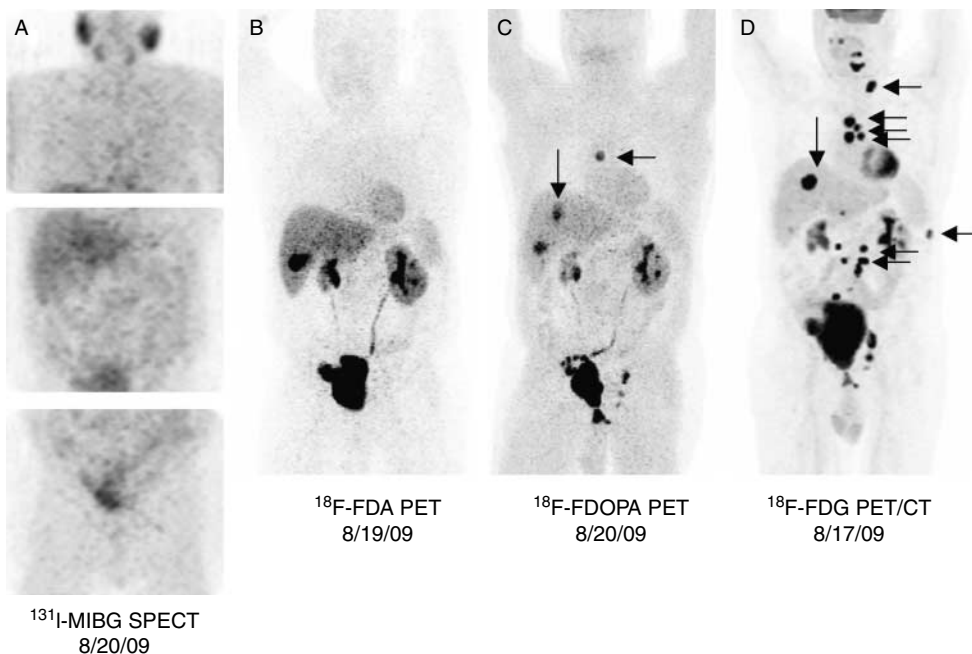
Nuclear imaging studies of a 55-year old male with metastatic pheochromocytoma who tested negative for succinate dehydrogenase B, C, and D mutations. The primary tumor was found in the urinary bladder and was removed with en bloc cystectomy, prostatectomy, with lymphatic node dissection and creation of ileal neobladder in 2005. In 2009, he was diagnosed with metastatic disease with false-negative ^{123}I -MIBG SPECT/CT. At NIH, (A) ^{123}I -MIBG SPECT/CT was also negative, but other nuclear imaging such as (B) ^{18}F -FDA, (C) ^{18}F -FDOPA, and especially (D) ^{18}F -FDG PET showed multiple metastatic foci in the lymph nodes, lungs, and liver. He underwent radiofrequency ablation of liver lesions. A repeat ^{18}F -FDG PET/CT after 3 months showed evidence of progression.
